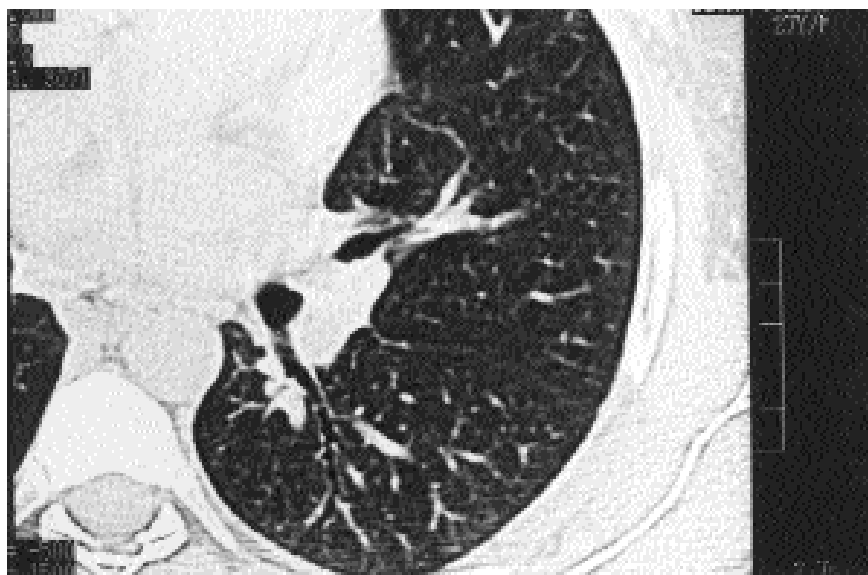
HRCT, left lung: One dilated bronchus at the apical segment of the lower lobe is sectioned longitudinally. The "string of pearls" configuration and peribronchial thickening are apparent.
